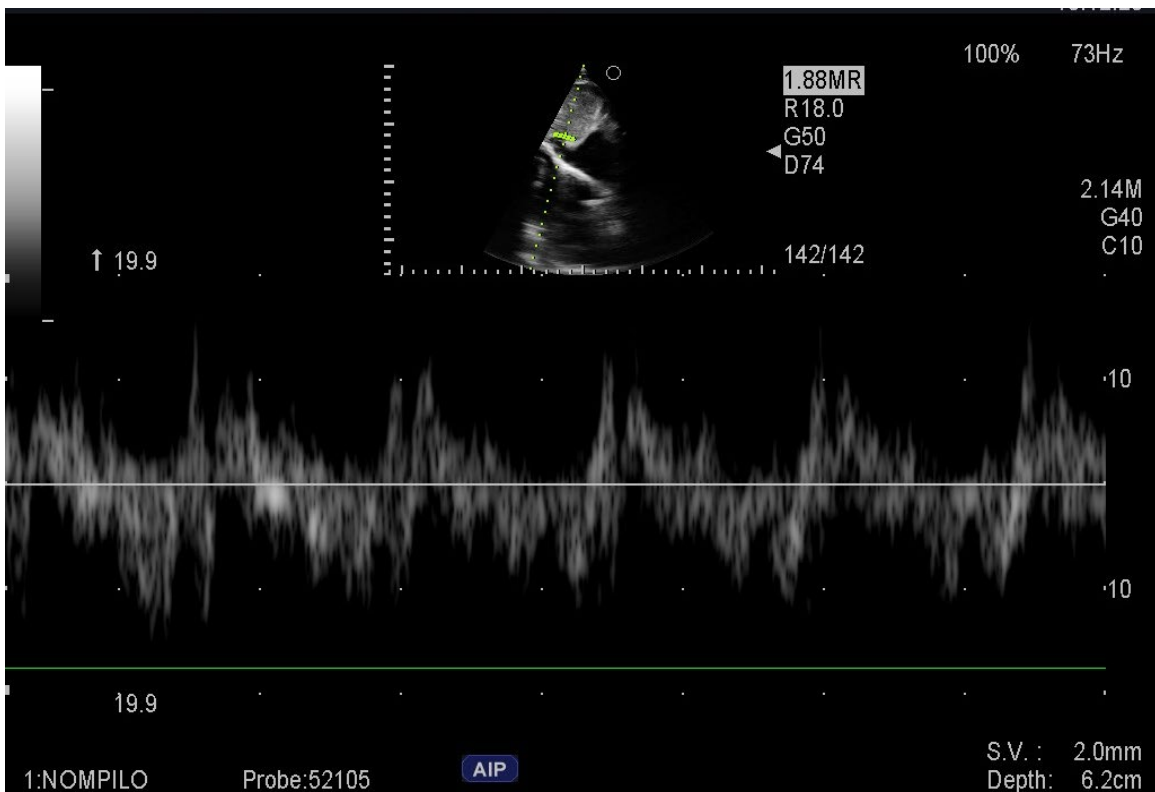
Pulsed Doppler of the hepatic vein.
